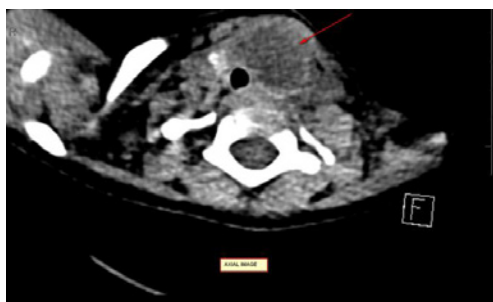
CT scan neck axial and sagittal view showing abscess.
